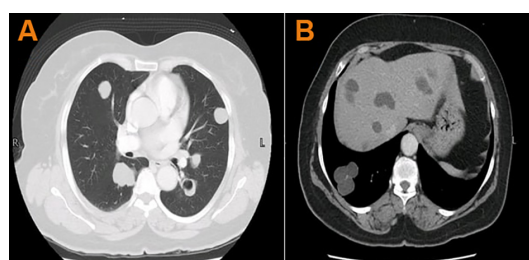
CT scan chest with contrast (A) showing multiple well-defined rounded soft tissue densities in both lungs, (B) lungs and liver.
